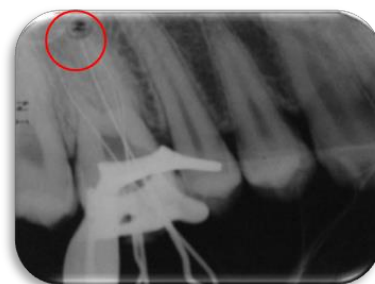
The raised dot is not placed in the slot of x-ray holder
